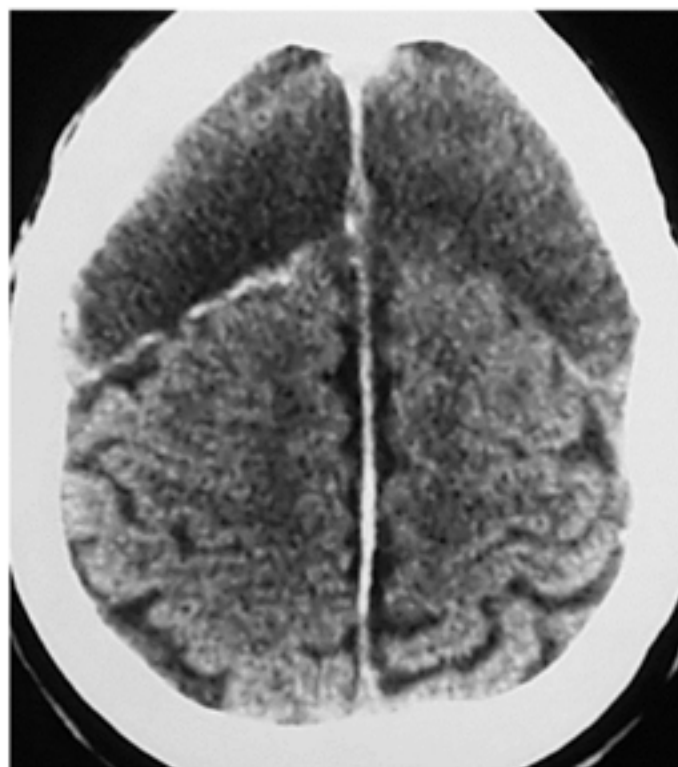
CT brain scan showing extensive bilateral chronic subdural hematoma involving frontal lobes.
